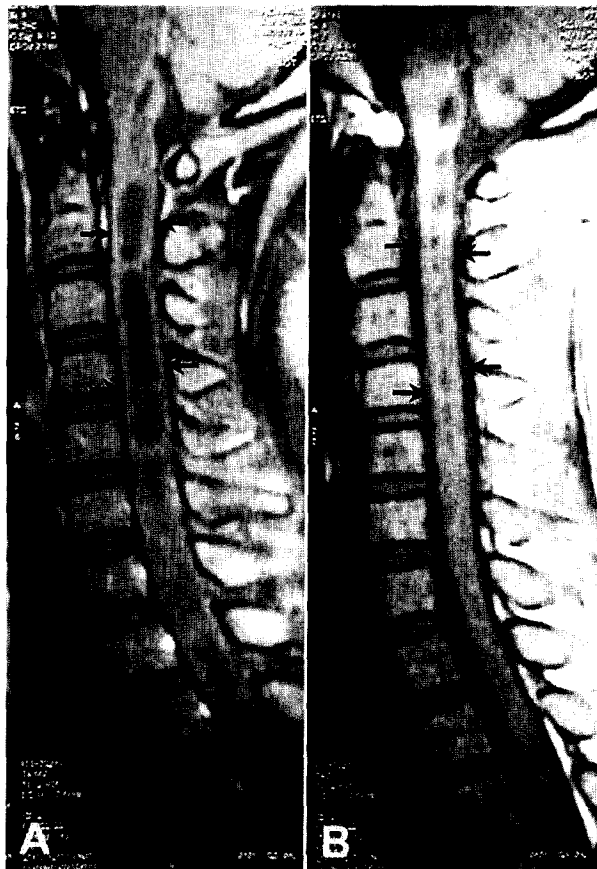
T1-weighted sagittal MR images of the cervical spinal cord. (A) Preoperative MR shows extensive syrinx with septations at the cervical cord (arrows) and lower part of the medulla. (B) Postoperative MRI shows collapse of the syrinx (arrows).
